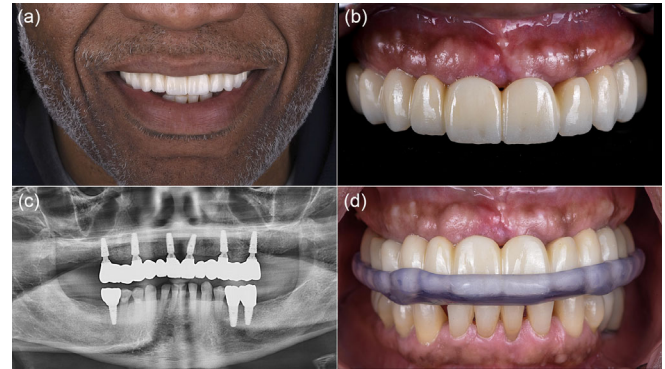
Definitive restorations were placed. (a) Posttreatment extraoral view of smile. (b) Posttreatment intraoral presentation. (c) Posttreatment panoramic radiograph. (d) 3D-printed occlusal splint.
